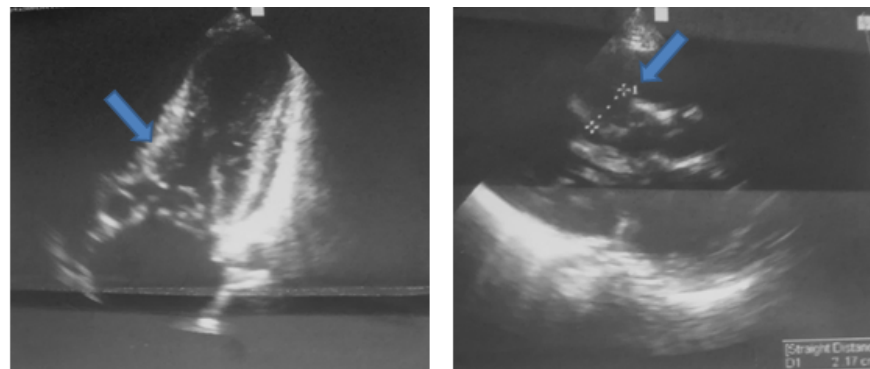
transthoracic ultrasound centered on the left ventricle (longitudinal view) showing asymmetrical thickening of the left ventricular wall, especially the septum (arrow)
